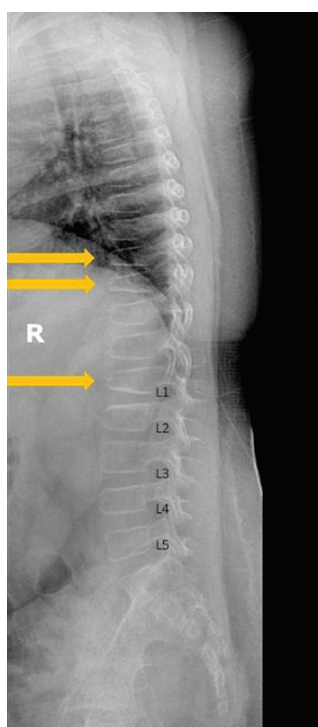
Lateral spine X-ray demonstrated multiple vertebral compression fractures at T9, T10 and L1 (yellow arrows) with generalized osteopenia.
